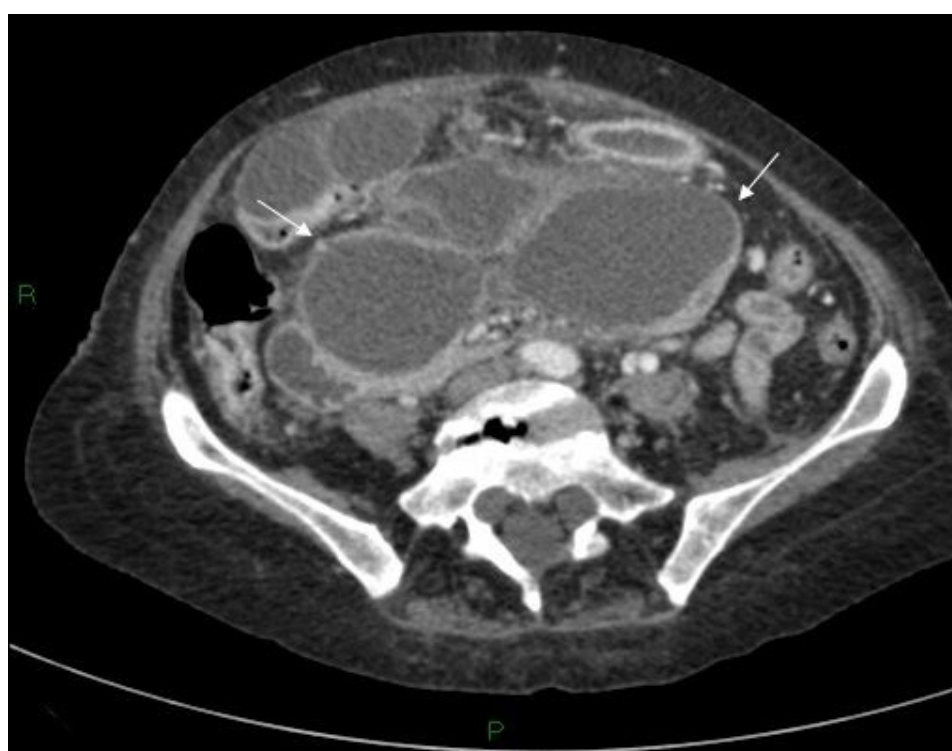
Axial post-contrast CT scan of the upper abdomen showing the inferior aspect of the cyst with bi-lobed appearance (arrows) in the pelvis.
